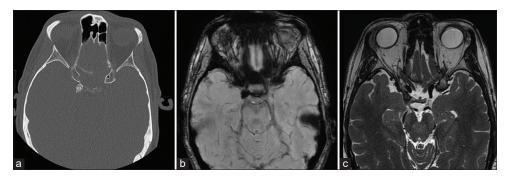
(a): Computed tomography (bone window, axial view) showing amorphous calcification of the right posterior clinoid process, (b): magnetic resonance imaging (MRI) susceptibility weighted imaging showing low signal within the lesion, (c): MRI T2-weighted image (axial view) showing low intensity of the lesion with oculomotor nerve entering posteriorly.
